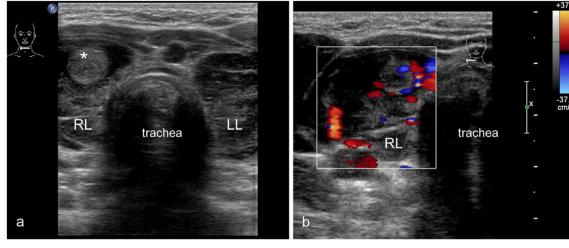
Thyroid ultrasound at admission. a Right (RL) and left (LL) thyroid lobes showed a strikingly enlarged volume (total volume 37 ml), an inhomogeneous echo texture, and a small single nodule (*) with a hypoechogenic margin. b Color doppler ultrasound of the right
